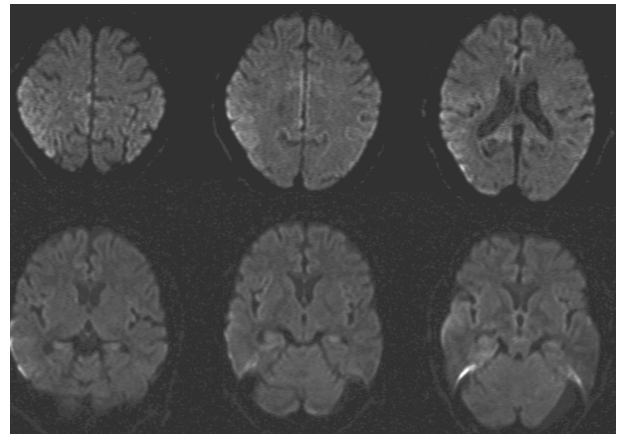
Follow up MRI, performed on 20th hospital day. Despite focal dystonia is continued, striatal signal changes are not shown on diffusion-weighted images.
